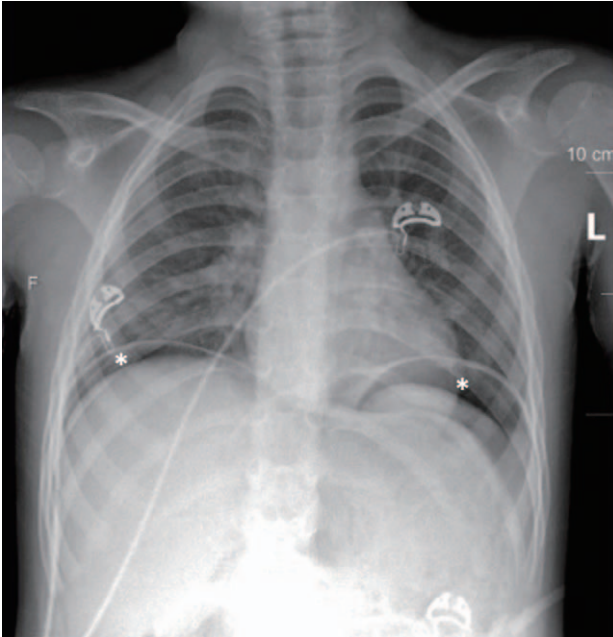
Plain supine radiograph showing free air (asterisks) under the diaphragm.
